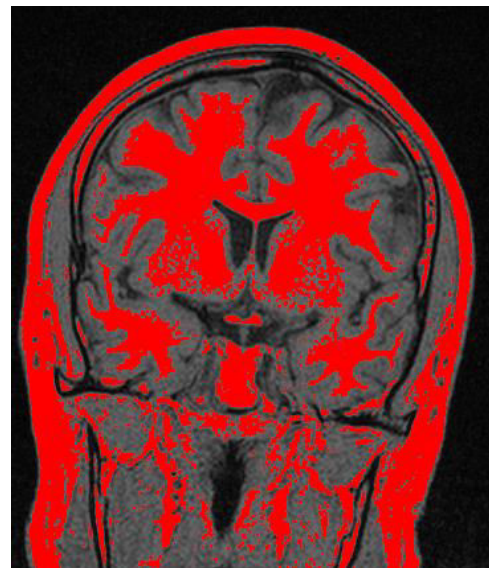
A coronal MR image of the brain. Application of the threshold for white mater.
